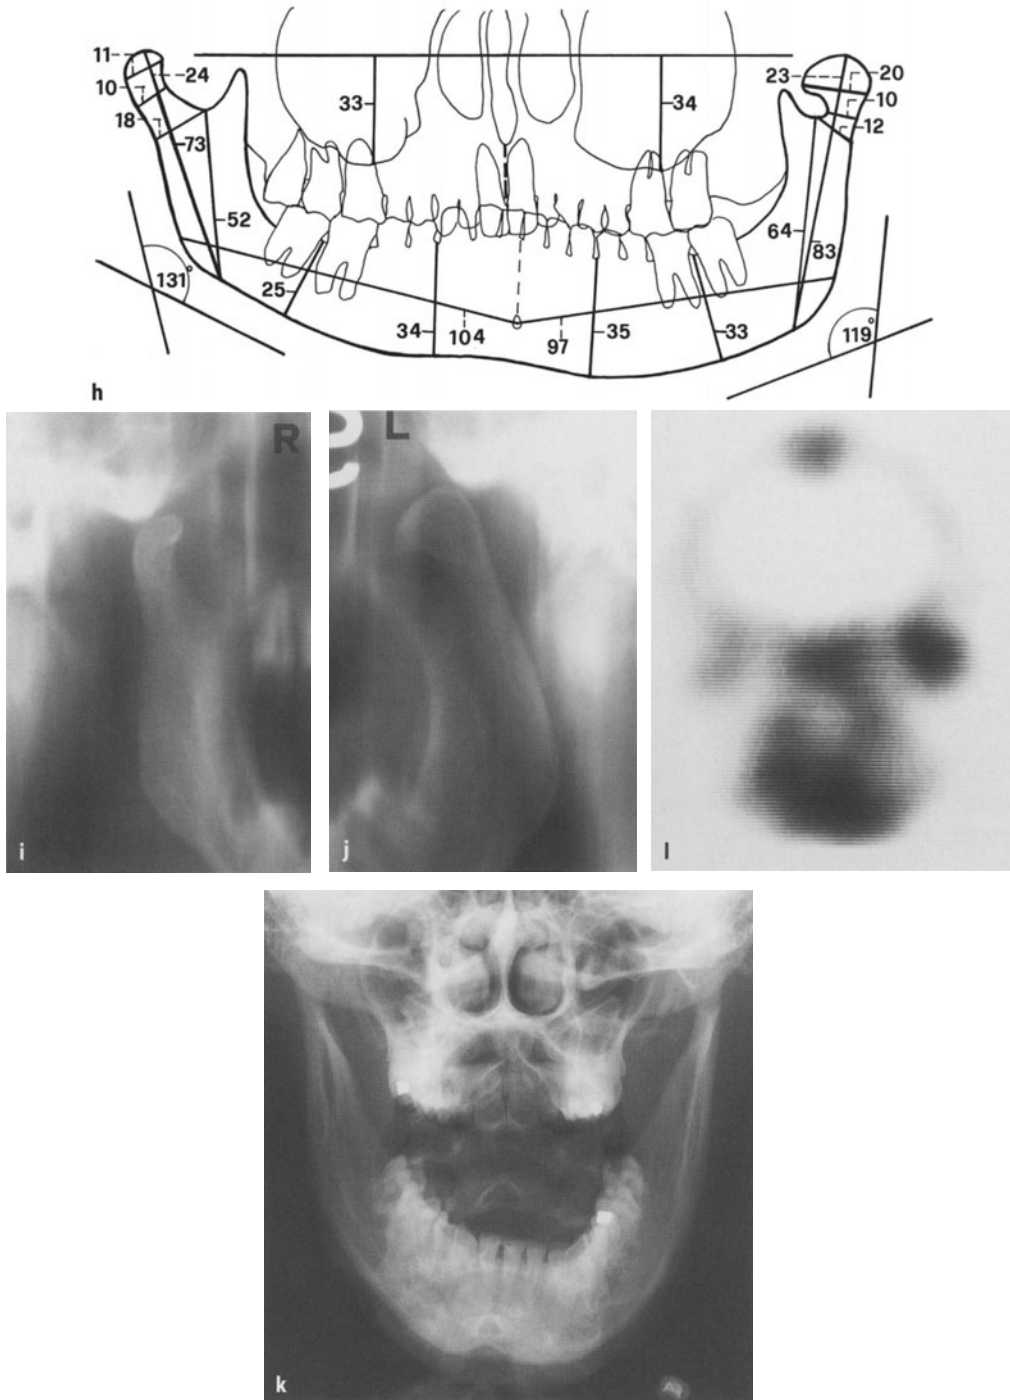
Unilateral highly active H.H. commencing after general growth has ceased and contralateral inactive slight H.E. h The measurements of the tracing of the panoramic view prove that there is a left side H.H. and a right side H.E. anomaly. i, j The TMJ ramus tomograms also prove the diagnosis clearly. k The mandible p.a. projection at maximum opening is not really significant for two different condylar growth anomalies. l The scintigraphy demonstrates clearly that there is very massive hyperactivity on the left side
